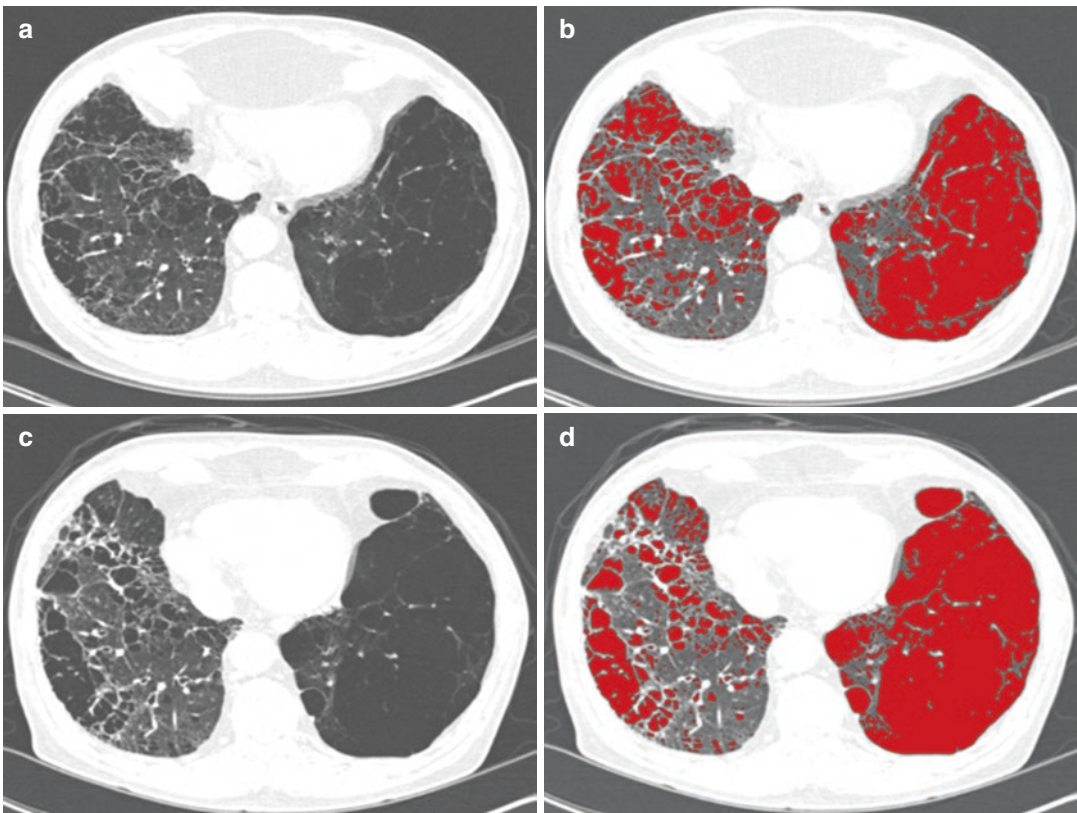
Follow-up emphysema quantification (LAA, %) in same subject. Initial emphysema index (EI, %) was measured to 41.8% on CT image (a) and matched color
